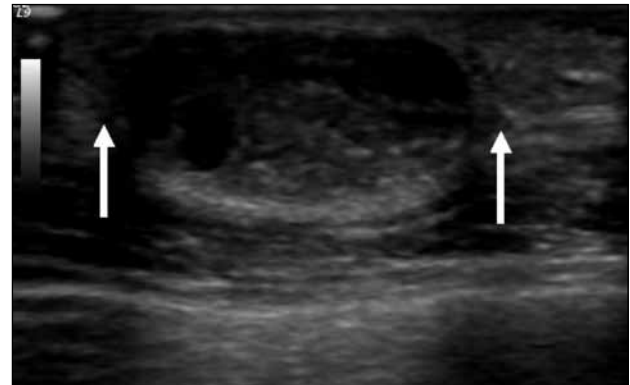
Epidermal inclusion cyst: ultrasound shows a hypoechoic lesion with posterior enhancement and contiguity with the epidermis (arrows), and the claw sign.
